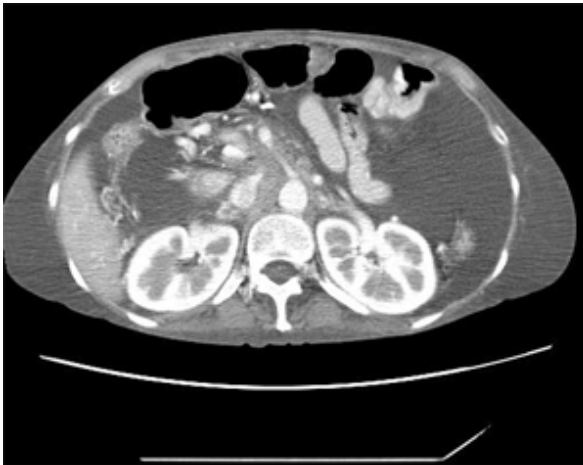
Abdominal enhanced CT scan shows lymphadenopathy encasing portal vein with stenosis.
